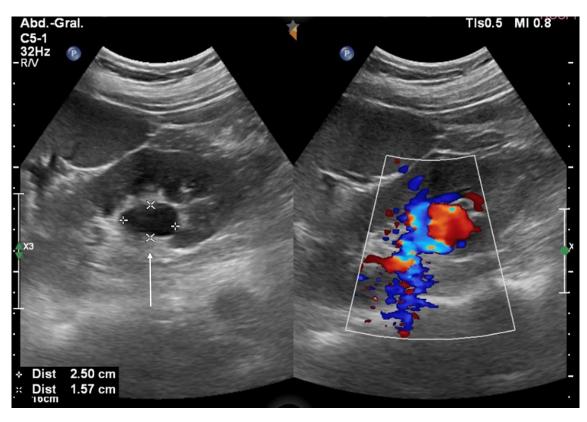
Color Doppler Ultrasound. Aneurysmal dilation of the inferior segmental artery with a yin-yang pattern measuring approximately 25 x 15 mm at the lower pole of the left kidney (arrow). Author's File.
